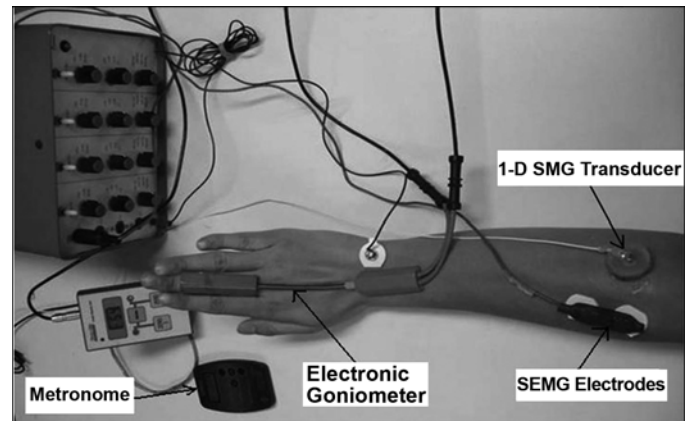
Placement of one-dimensional sonomyography (1-D SMG) transducer, surface electromyography (SEM) electrodes, and electronic goniometer on forearm. Ultrasound coupling gel was applied between transducer and skin.
